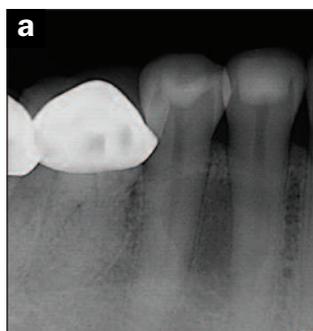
A unique location for a radiolucent lesion can be seen on the initial digital periapical radiograph.
